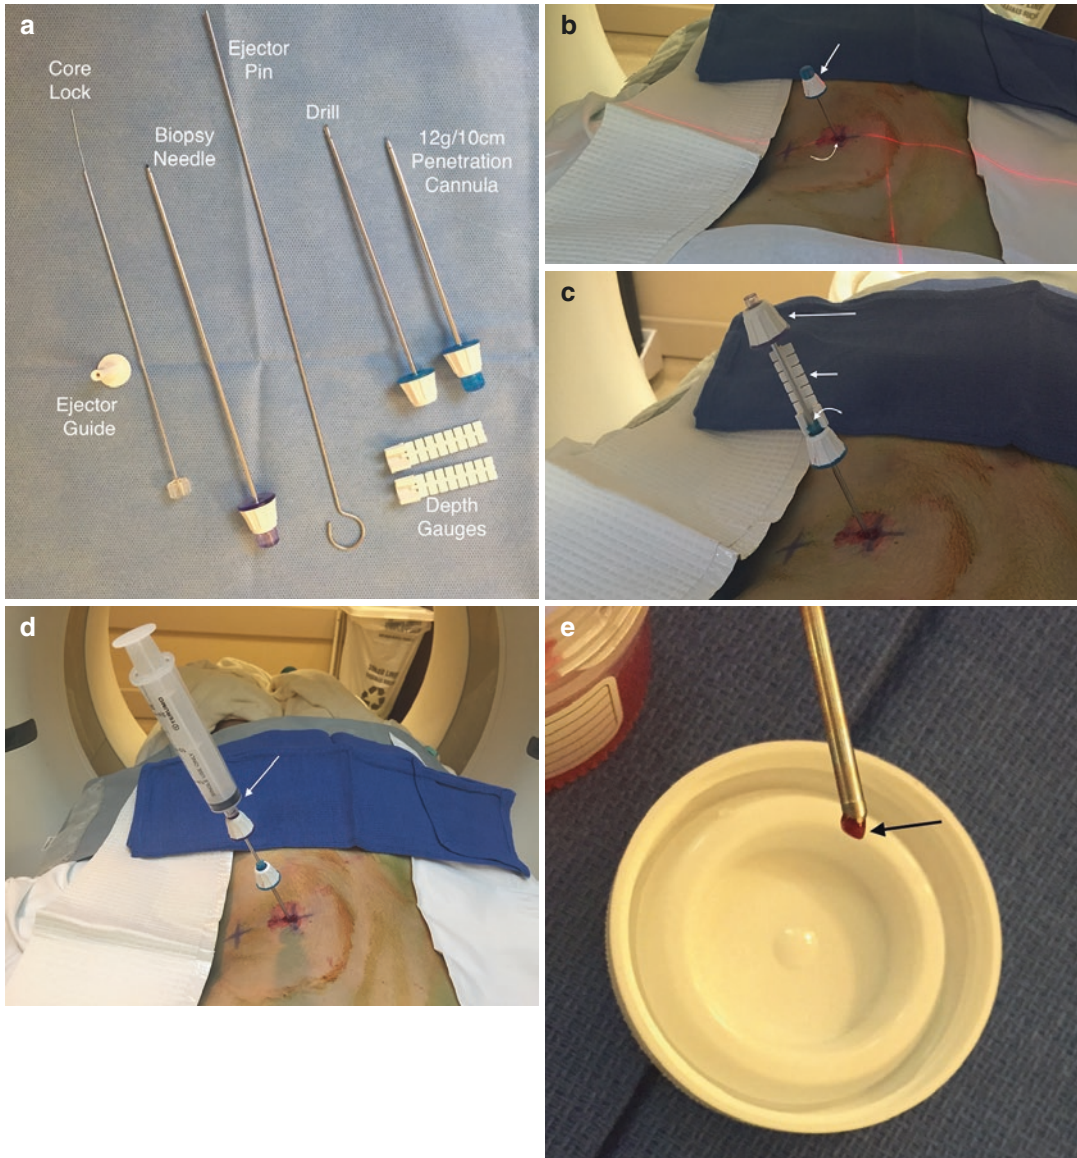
Photograph of a bone biopsy system (a) that includes a trapping mechanism or core lock for the biopsy core within the bone cannula. Actual case demonstration (b) of inserted penetration cannula (arrow) using CT guidance; note the skin mark and laser line (curved arrow). Use
